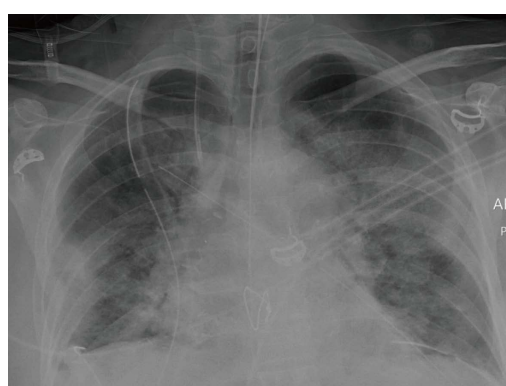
Chest X-ray 3 d post transplantation shows reperfusion oedema. Bilateral airspace opacity in the mid to lower zones and sub-pleural consolidation in the lower zone of the right lower lobe.
